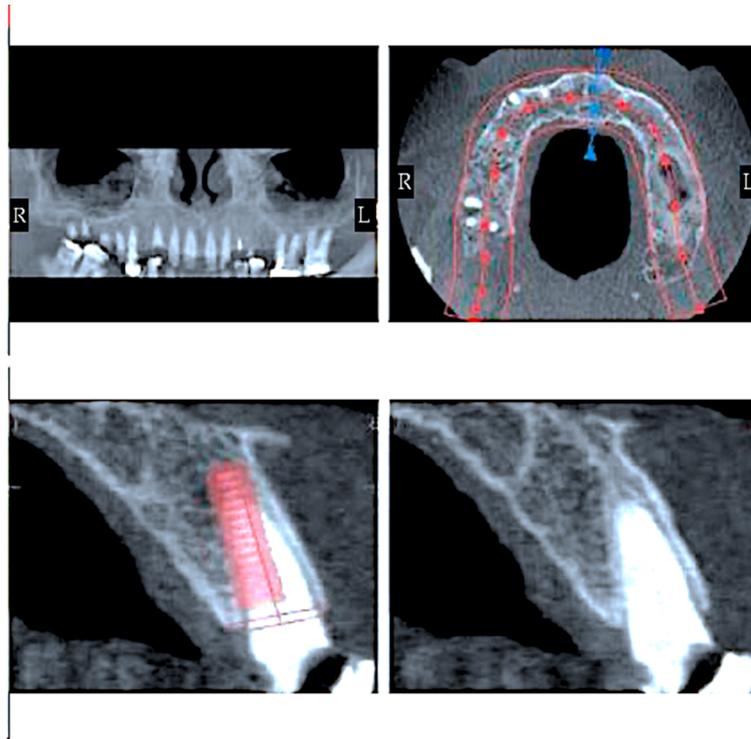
Cone beam-computed tomography planning in the maxilla [38].
